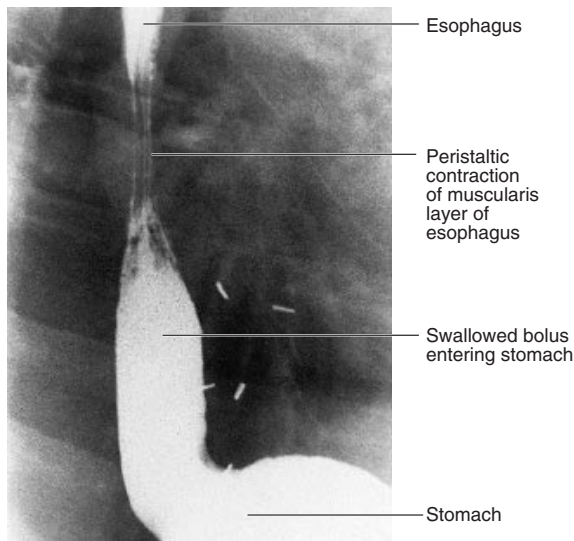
An anteroposterior radiograph of the esophagus showing peristaltic contraction and movement of a bolus into the stomach.
